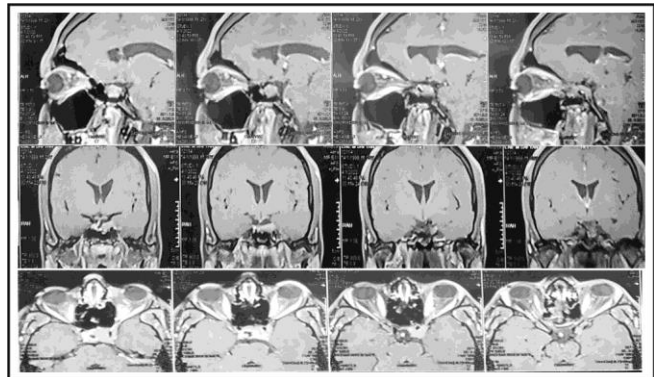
(A): Pre-op MRI Brain.
